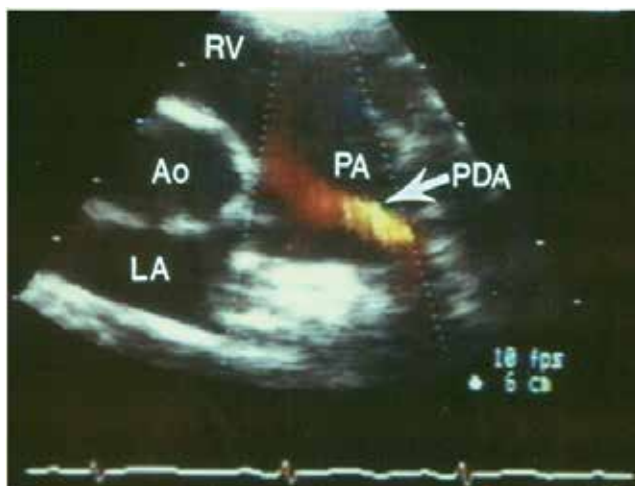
Color Doppler flow mapping of the main pulmonary artery (PA) in a parasternal short axis view demonstrating the flow of the patent ductus arteriosus (PDA). Ao, Aorta; LA, Left atrium; RV, Right ventricle
